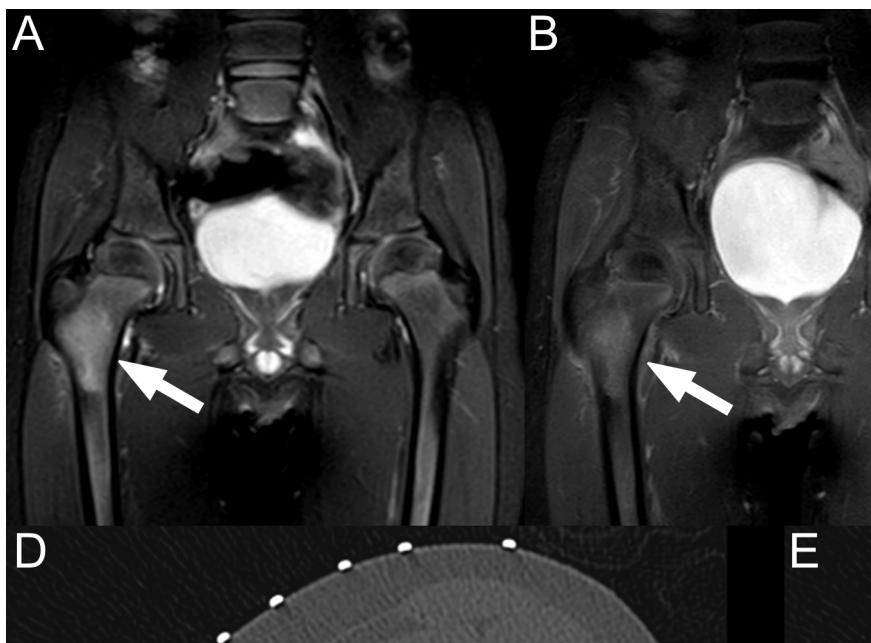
A 5-year-old boy without any relevant medical history presented with pain in the right hip and night sweats since one week. A conventional radiograph of the right hip (not shown) was unremarkable. Coronal fat-suppressed T2-weighted (A) and gadolinium-enhanced MRI (B) showed a T2 hyperintense and contrast-enhancing lesion in the proximal right femur (arrows) with some surrounding soft tissue induration. Coronal positron emission tomography (PET)/CT showed the lesion to be ^{18}F -fluoro-2-deoxy-D-glucose (FDG)-avid (C, arrow). There were no other FDG-avid lesions on whole-body PET/CT. The lesion is invisible on axial 2.0-mm pre-biopsy planning CT (D). Axial CT shows the tract of the biopsy (E). The acquired 4-mm tissue sample yielded insufficient material for a specific diagnosis to be made or to suggest a malignancy. All symptoms resolved with conservative treatment within one month, and the patient remained completely symptom-free at eight months follow-up. The lesion was therefore classified as benign.
